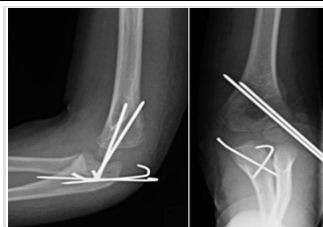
Anteroposterior and lateral view radiographs of the left elbow, at 3 weeks after surgery.
